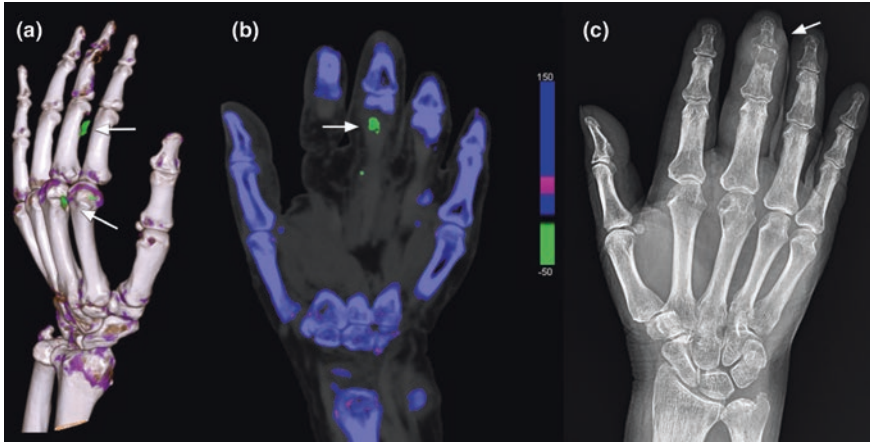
a 3D volumetric reconstruction from a dual-energy CT study showing areas of uric acid deposition (white arrows) in a patient with gout. b Coronal dual-energy CT reconstruction showing uric acid deposition (arrow). c Hand radiograph of the same patient showing dactylitis of the middle finger (arrow) but no visible tophi
